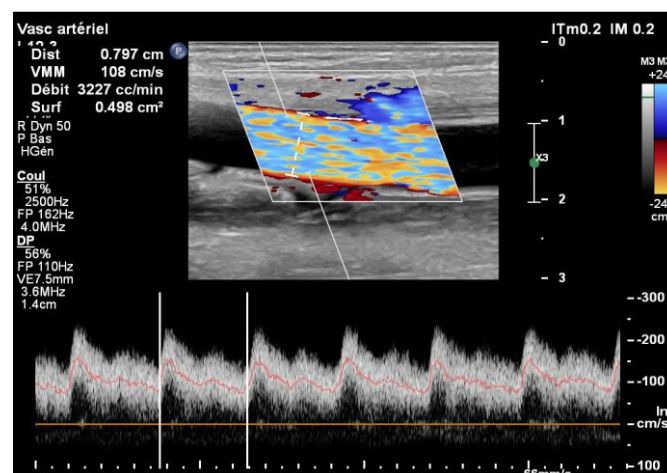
Color Doppler ultrasound of the right upper limb demonstrated High flow of the brachio-brachial arteriovenous fistula
